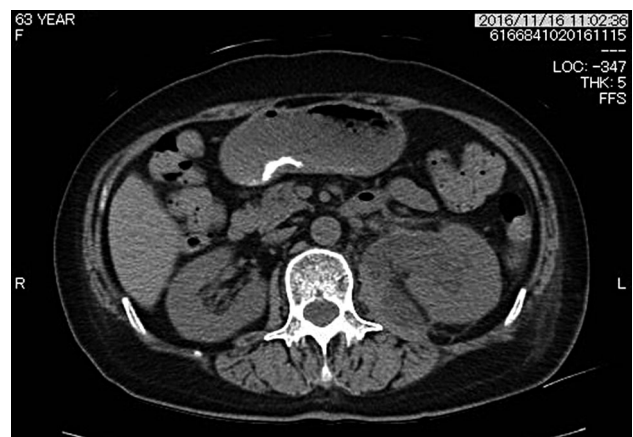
CT examination of the abdomen, which demonstrates a left hydronephrosis with tight stricture in the upper part of the ureter.
